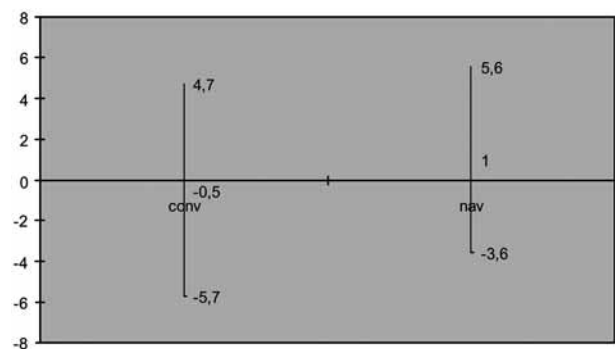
Average postoperative rotational alignment of femoral component and maximum deviations (rotational position in degrees : angle between transepicondylar axis of distal femur and transverse axis of implant on CT scan). Mean values and 95% confidence intervals. Negative values represent external rotation.
